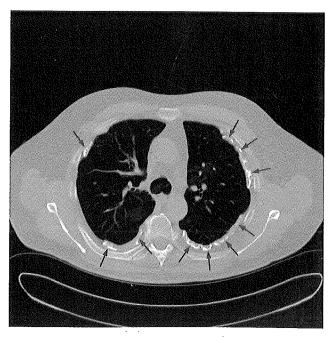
Chest CT showing extensive calcified pleural plaques (*arrows*) associated with asbestos exposure.
